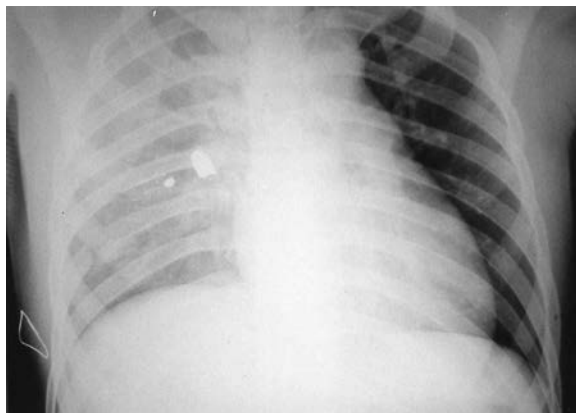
Chest x-ray showing the use of markers to show the wound track.
